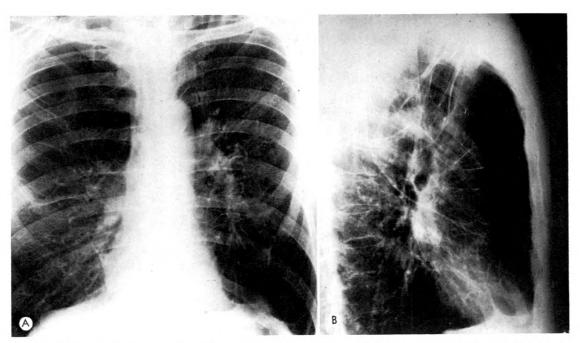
(A and B) Roentgenograms of a 45 year old white man with dyspnea, cough and marked decrease in exercise tolerance (chronic pulmonary insufficiency). Note the bullae in the right upper and left lower lobes which contain large amounts of "dead" air. Since the blood in the pulmonary arteries which flows through these areas does not receive O₂, a vascular shunt is present. Note, also, the irregular pattern of the lung markings in the lateral view. This indicates nonuniform distribution of air throughout the lungs.
